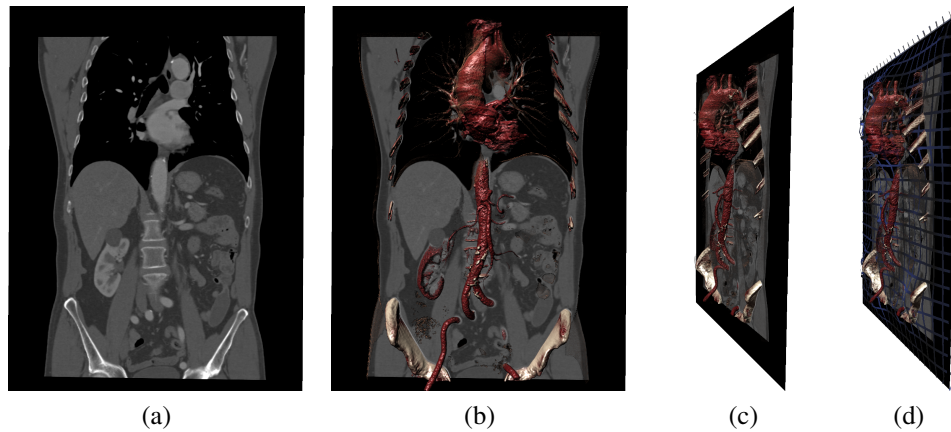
Rendering of a medical CT dataset. Compared to the regular slice view (B.3a), adding local DVR provides interesting structures out of the plane (B.3b). Figure B.3c shows a tilted view of the same plane and the grid in Figure B.3d shows the deformed membrane.
